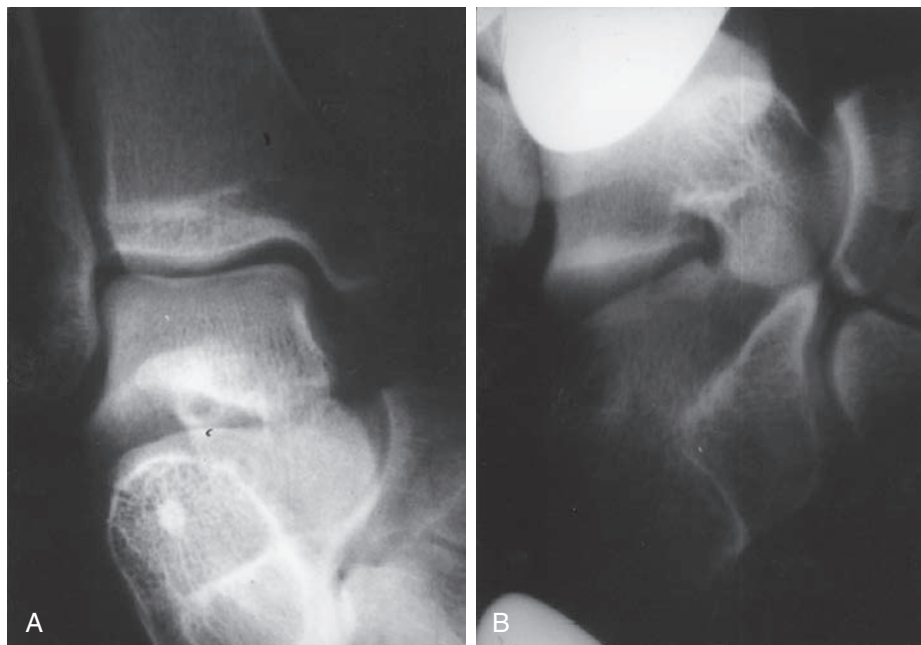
Stress radiographs. (A) Stress anterior-posterior (AP) radiograph with subtalar tilt. (B) Stress Broden view showing subtalar instability.
